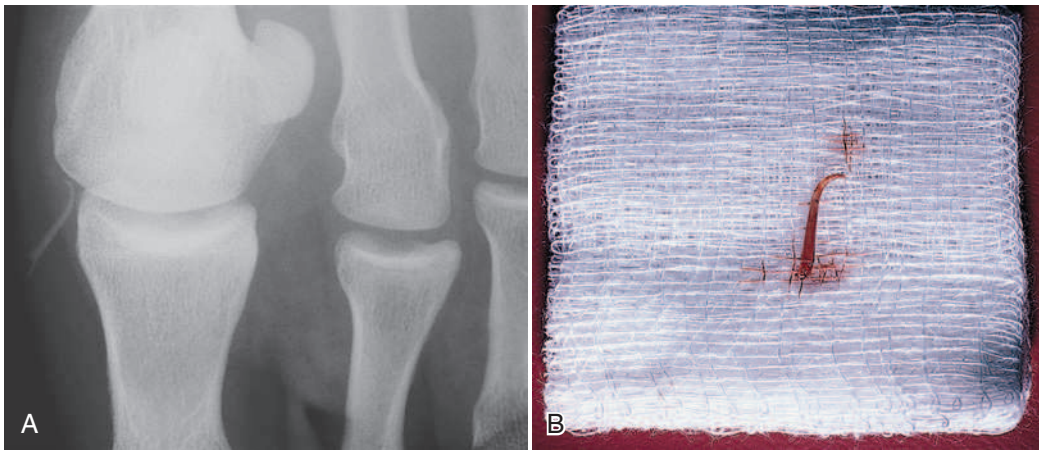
Catfish spine lodged in the foot. A, Radiograph shows a foreign body. B, The spine removed. (Courtesy Paul S. Auerbach, MD.)
